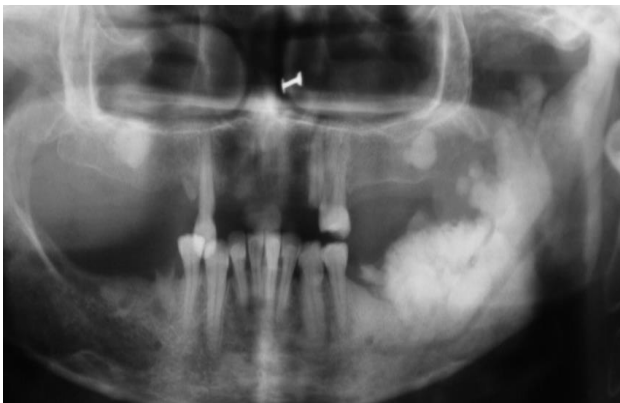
Panoramic radiograph revealed increase in size of the radio-opacity with extension upto the left sigmoid notch.
